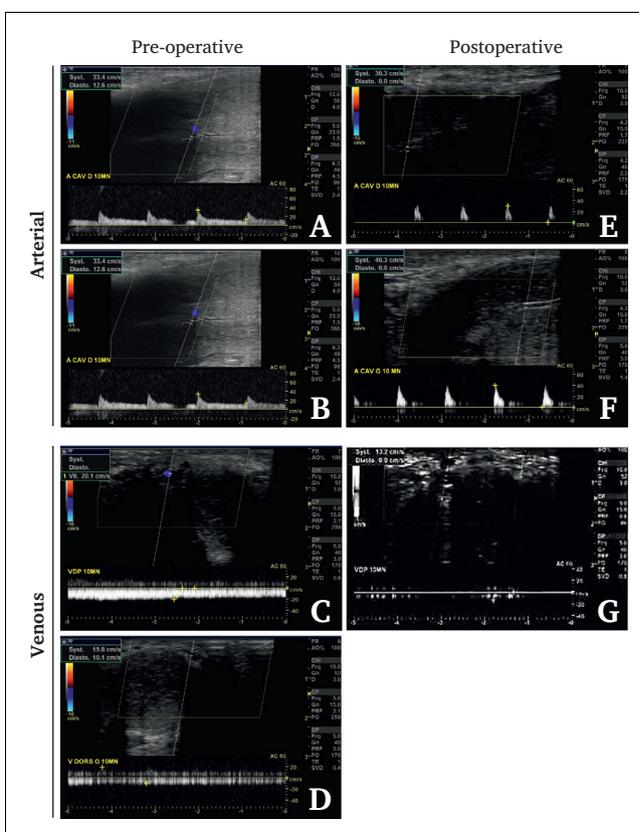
(A–D) Pre-operative and (E–G) postoperative penile pharmacologically challenged duplex sonograms 10 min after intracavernosal injection of vasoactive drugs in the same patient treated for drug resistant erectile dysfunction caused by cavernovenous leakage. (A, B) Arterial function assessed by peak systolic velocity in the (A) right and (B) left cavernosal arteries. Venous occlusive function is compromised, as shown by the end diastolic velocity >5 cm/s (here: 16 cm/s). (C) Venous occlusive function compromised by abnormal leakage of the deep dorsal vein (DDV; here DDV velocity: 59 cm/s). (D) Leakage in an abnormal superficial vein (superficial vein velocity). (E, F) Three months after surgery, end diastolic velocity was 12 cm/s in the (E) right and (F) left cavernosal arteries. (G) Absence of leakage from DDV. Superficial vein velocity undetected (not shown).
